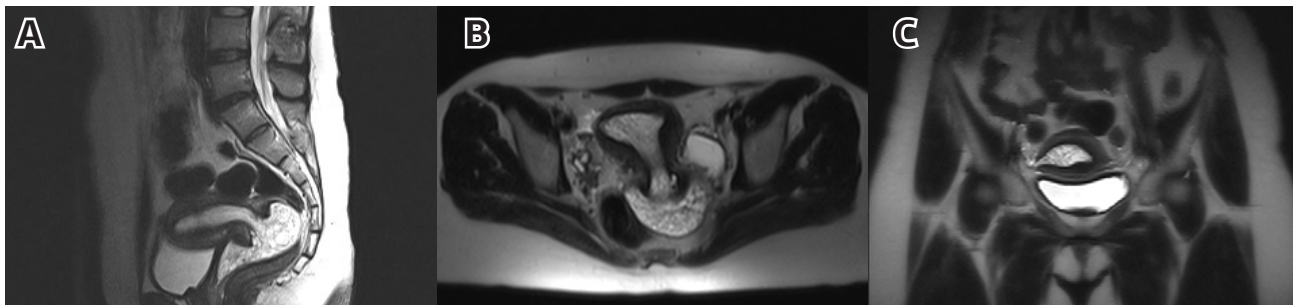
T2W sagittal (a) axial (b) and coronal (c) MR images. A heterogeneous lesion within fluid intensity located in uterus extending bilateral tuba and proximal part of vagen is seen.
